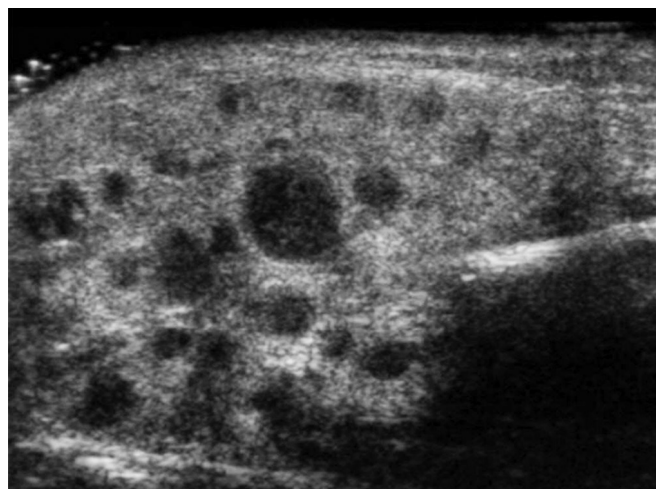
Longitudinal ultrasound image shows multiple well-defined hypoechoic foci within the right parotid gland. The larger lesions likely represent small intraparotid lymph nodes and the smaller lesions are most likely microabscesses or dilated acini.
